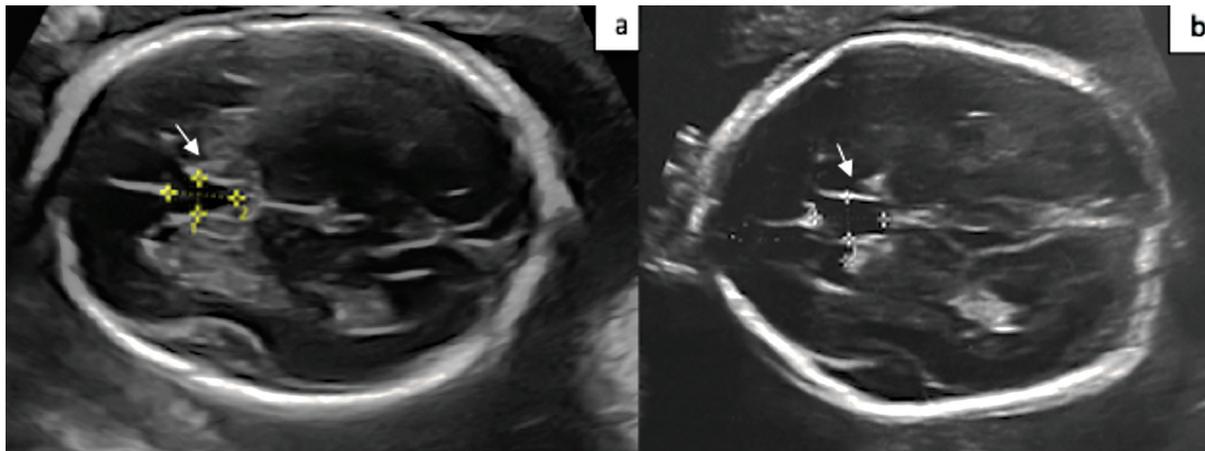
Two-dimensional ultrasound images of the cavum septi pellucidum (white arrow) in a euploid fetus (a) and in a fetus with trisomy 18 (b).
